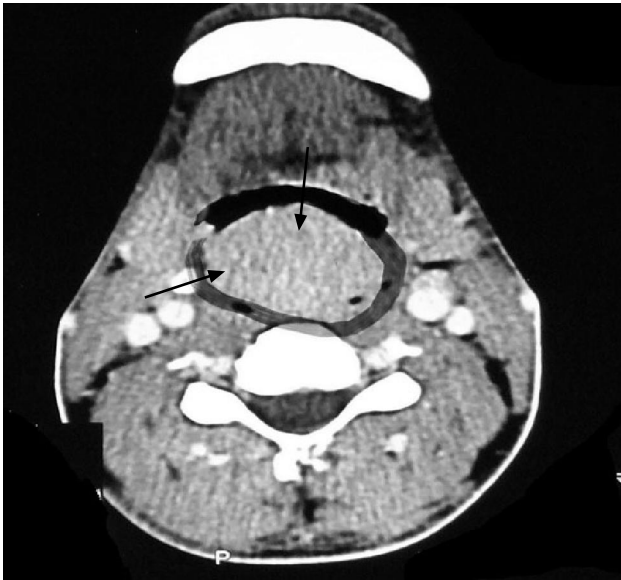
Axial image of CT neck (Black arrows showing large laryngeal mass)
